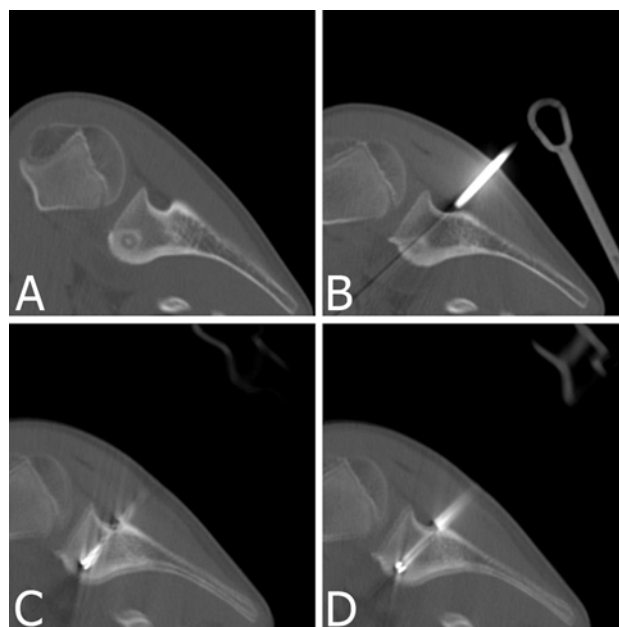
RFA for a 6-mm-diameter OO in the neck of the scapula in an 11-year-old boy is shown. The posterior approach is used to avoid anterior neurovascular structures. CT scans show (A) the medullary nidus with surrounding sclerosis, (B) driving the coaxial guide toward the nidus, (C) drilling the track up to the nidus, and (D) the radiofrequency needle in the nidus.
